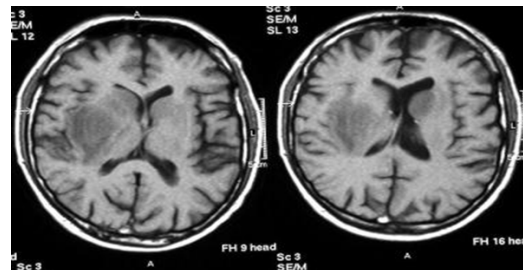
Nonenhanced T1-weighted images in a patient infected HIV and cerebral toxoplasmosis. These images show hypointense, asymmetrical, bilateral periventricular/basal ganglial lesions.
